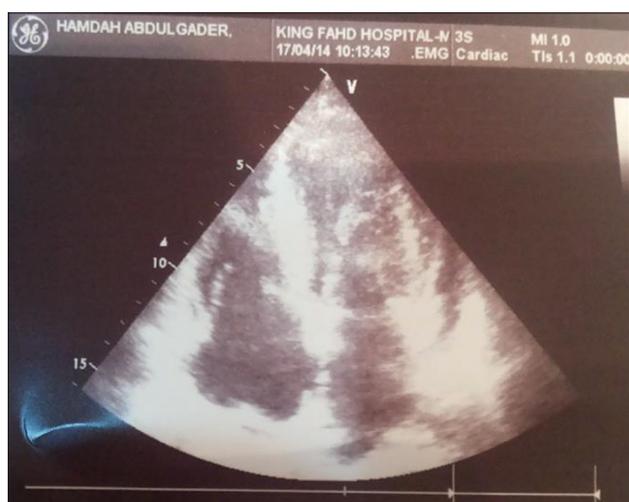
Echocardiograph vegetation disappear at 5 weeks
